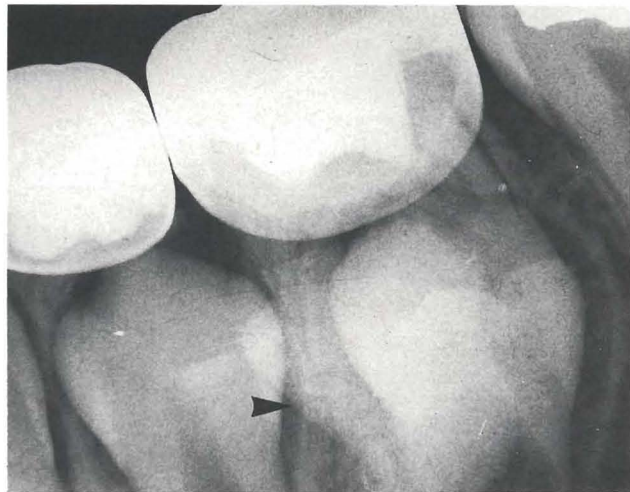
Pretreatment radiograph of the same area taken a year ago with no signs of such radiopacity.
